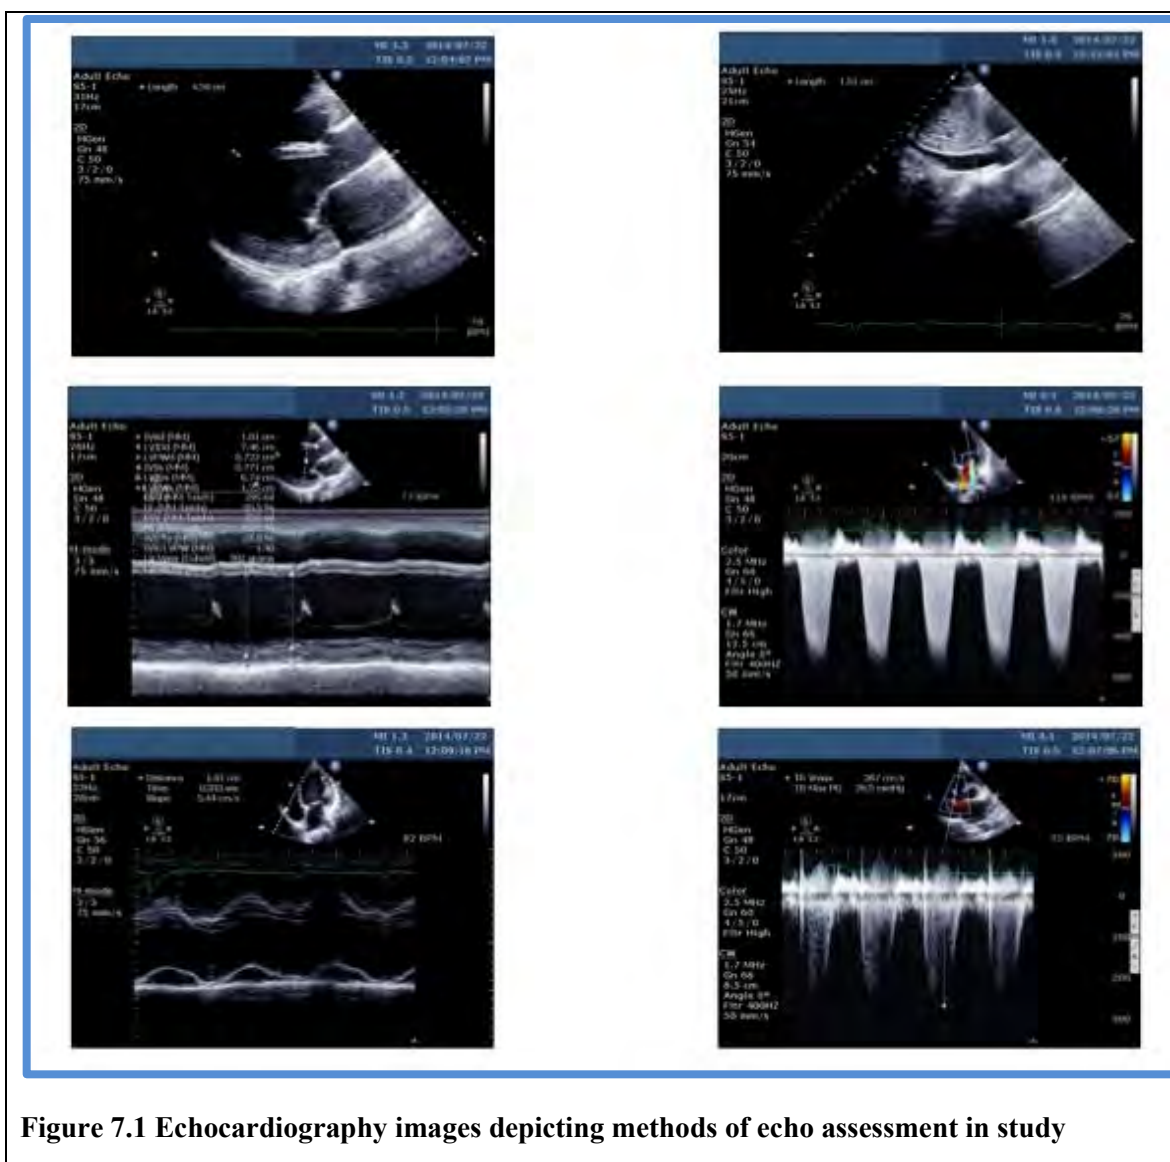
Echocardiography images depicting methods of echo assessment in study
